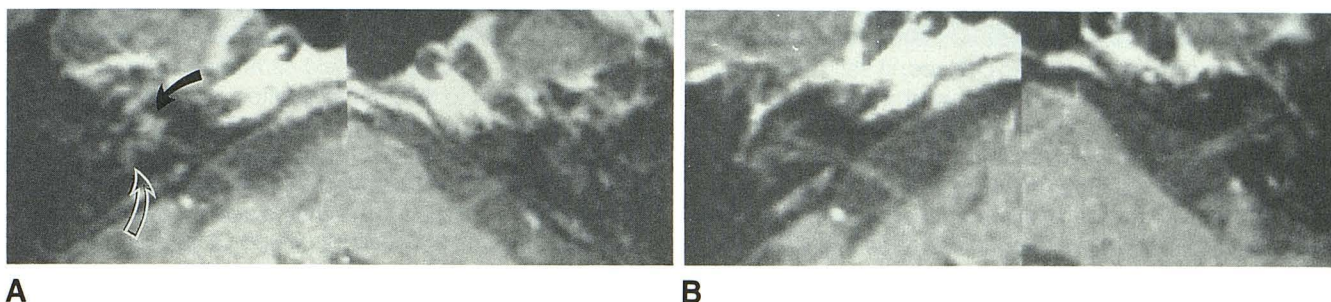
Case 4: Axial T1-weighted enhanced images, 600/20/2, in patient with right-sided hearing loss and vertigo with only minimally abnormal electronystagmogram.
